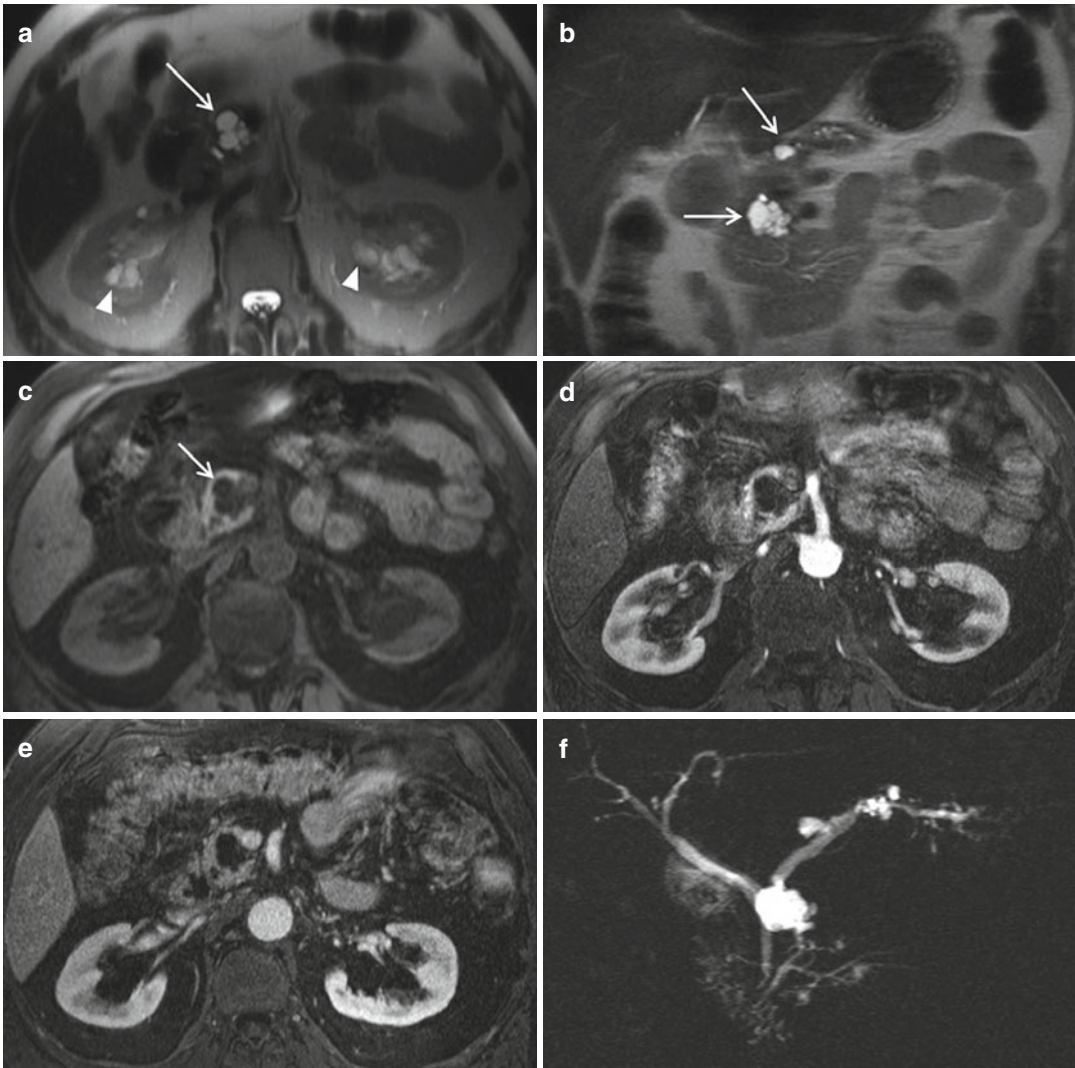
A 57-year-old female patient with multifocal branch-duct IPMNs and main-duct IPMN (mixed IPMN). (a, b) Axial (a) and coronal (b) T2-weighted images: multiple cystic dilations of pancreatic branch ducts (arrows) are visible along the whole gland, hyperintense compared to the surrounding parenchyma; main pancreatic duct is dilated, too; note the presence of multiple cysts in the kidneys (arrowheads). (c) Axial T1-weighted GRE image
